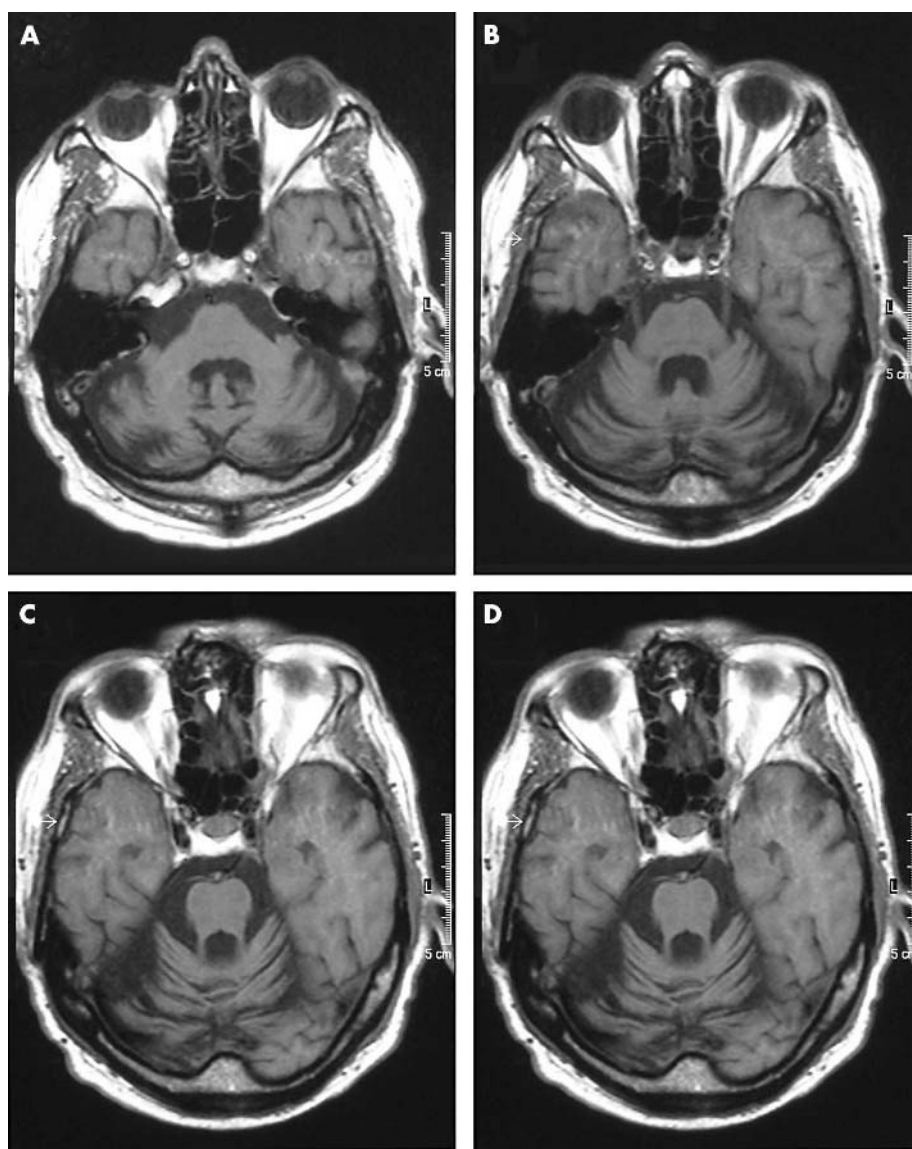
MRI scan of the cerebrum of individual III:15 showing atrophy of the cerebellum, vermis, medulla oblongata, and pons.
